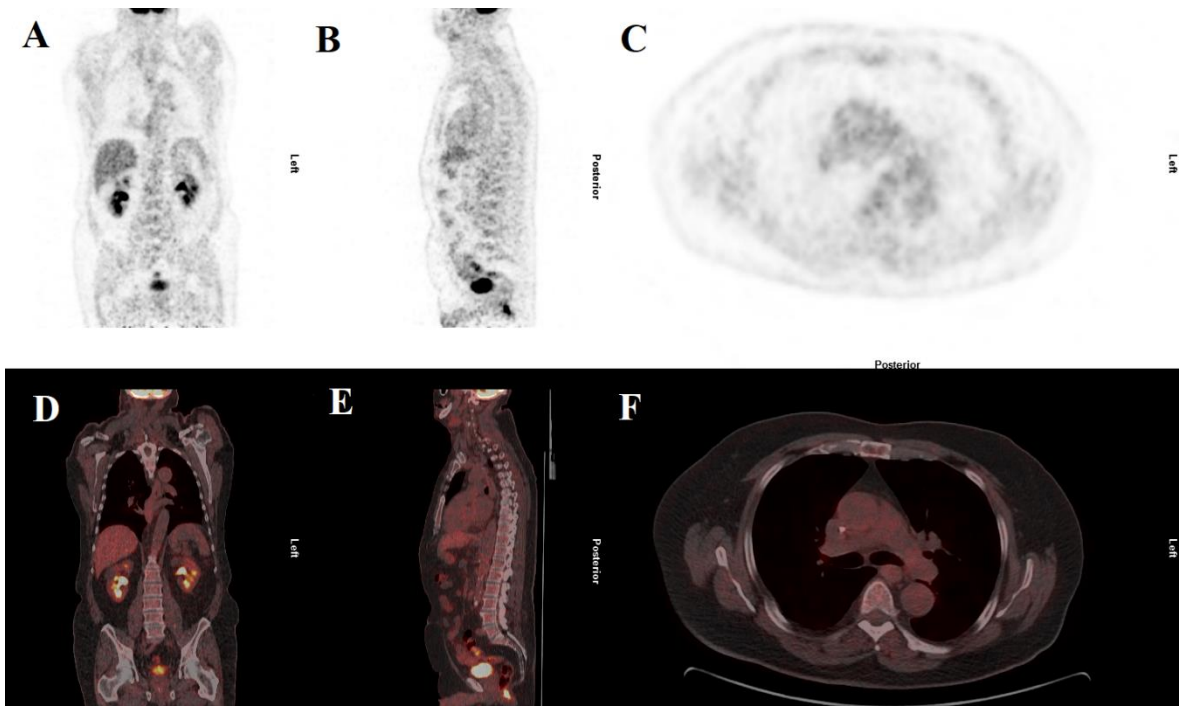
^{18}F FDG-PET/CT images in unfused and fused states of the same patient as in figure 7, at follow-up examination four weeks following completion of neoadjuvant chemo-radiotherapy. There is no remaining pathological uptake in the tumour.
